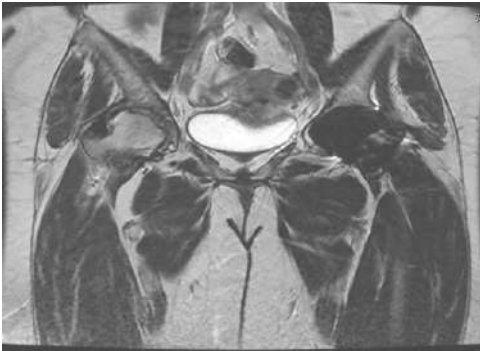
MRI of the right hip joint 14 months post procedure (February 2022) - As Shown in Fig3a and 3b.
